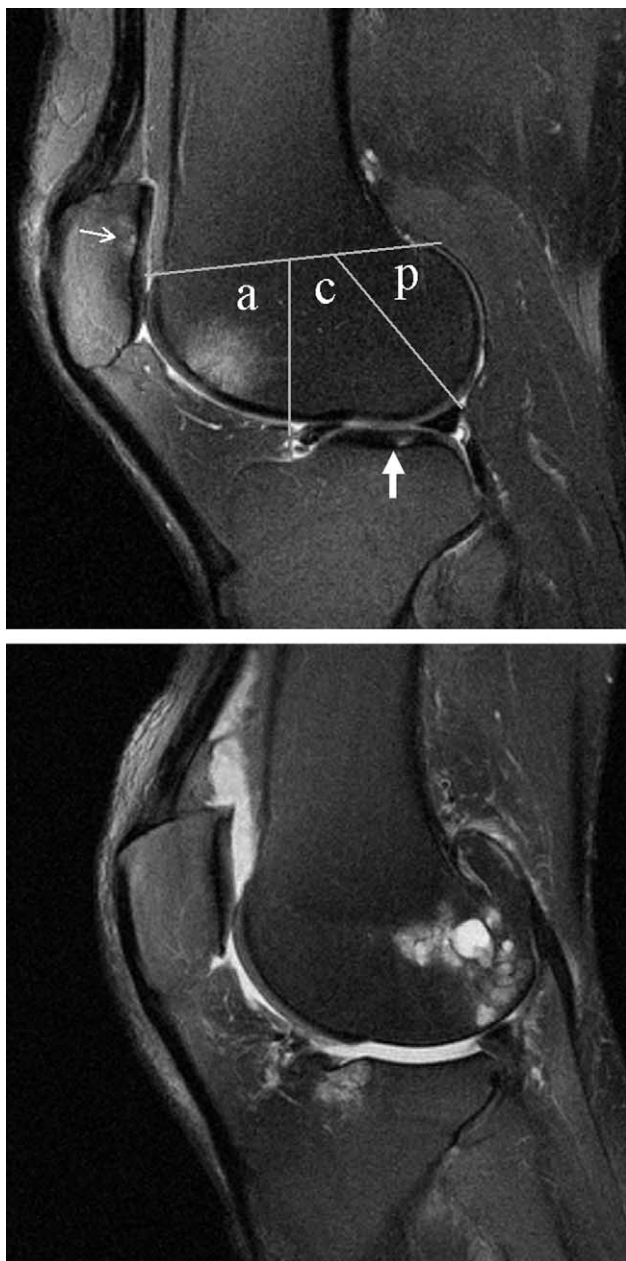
Sagittal T2-weighted FSE. A. Focal grade 1 cartilage signal lesion (large arrow) is present in the LTC region, grade 3 cartilage loss over the LFP and LP, and grade 3 marrow abnormality in the LFA. Grade 1 subarticular cyst (small arrow) is noted beneath the thinned cartilage of the LP. This image also shows mild failure of fat suppression over the patella. This artifact occasionally arises in this location because the irregular shape of the patella perturbs the local magnetic field and alters the resonant frequency of fat, upon which frequency-selective fat suppression is based. Fat-suppression failure could easily be mistaken for marrow abnormality, except that the latter respects osseous boundaries, whereas frequency shifts often extend into the surrounding soft tissues. B. A milder example of this phenomenon is also seen in this image. Other findings include grade 3 subarticular cysts in LFP; complete denuding (grade 6) of articular cartilage over LFC, LFP and all three regions of LT; grade 3 marrow abnormality in LTA; grade 1 bone attrition across LT; grade 2 and grade 7 osteophytes of LTA and LFP, respectively; and grade 4 destruction of the anterior horn of the lateral meniscus.
